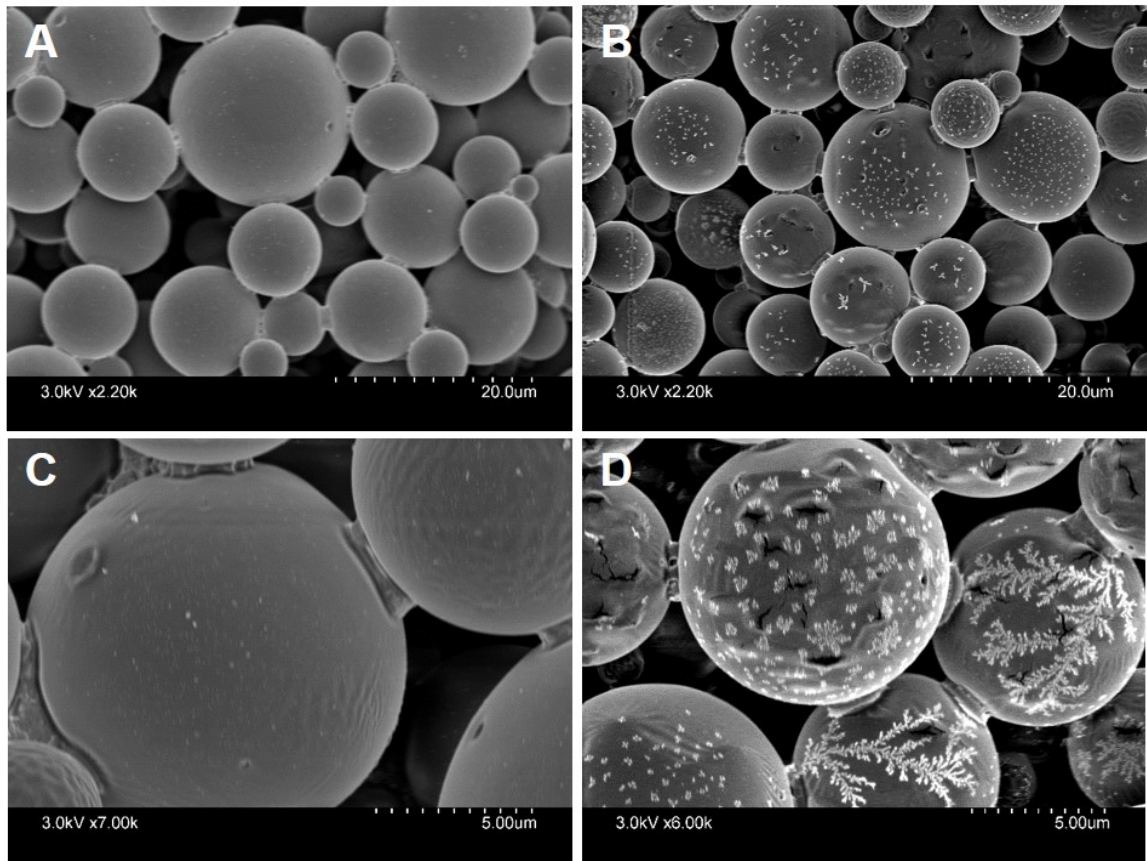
The morphology of PLGA microbubbles after ultrasound therapy. (A) Morphology of untreated PLGA microbubbles showing intact and smooth surfaces. (C) Higher magnification PLGA microbubbles without ultrasound exposure. (B) Morphology of ultrasound exposed PLGA microbubbles showing degradation or cracking in the surface. (D) Higher magnification of PLGA microbubbles in response to ultrasound exposure.
